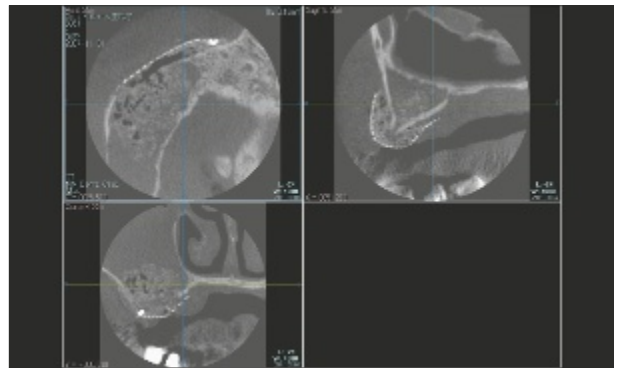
CBCT scan obtained after SFE and three-dimensional bone augmentation. Three-dimensional conditions were found to be ideal at the augmented site.
